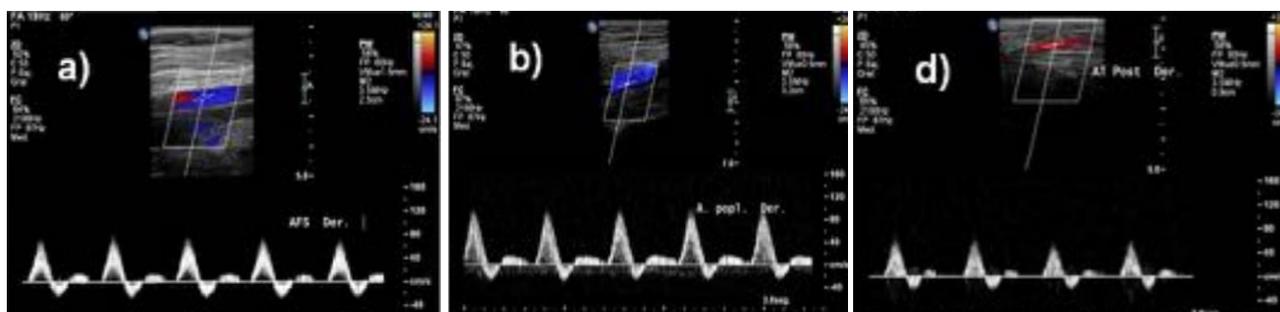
Arterial Doppler ultrasound of the right lower limb, color and arterial Doppler flow pattern a) Popliteal A. b) Anterior tibial A. d) Posterior tibial A
